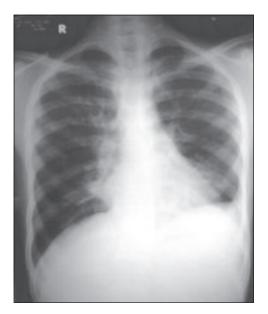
Chest X-ray (P/A): Lt. sided pleural thickening with fibrosis on both side.
